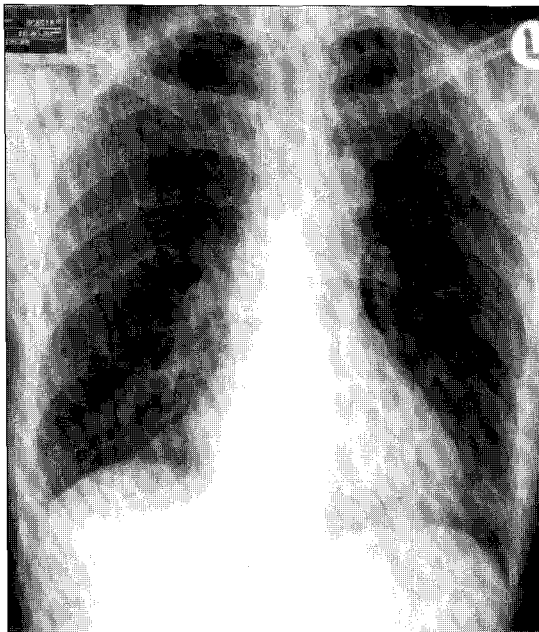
The chest radiography shows normal findings
